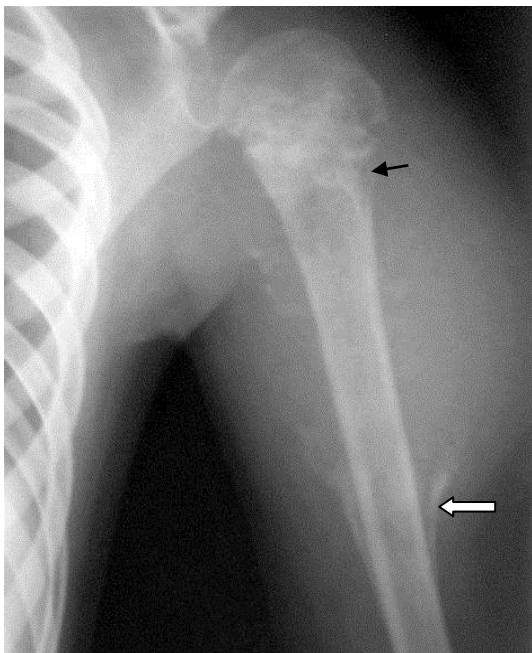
Radiograph of the humeral bone. Frontal view. In proximal metaphysis area of the humerus there are extensive sites of destruction with indistinct contours and destruction of the cortical layer (arrow). There are periosteal reaction in the upper third of the diaphysis – Codman's triangle (a figured arrow). Osteogenic sarcoma of the humeral bone
